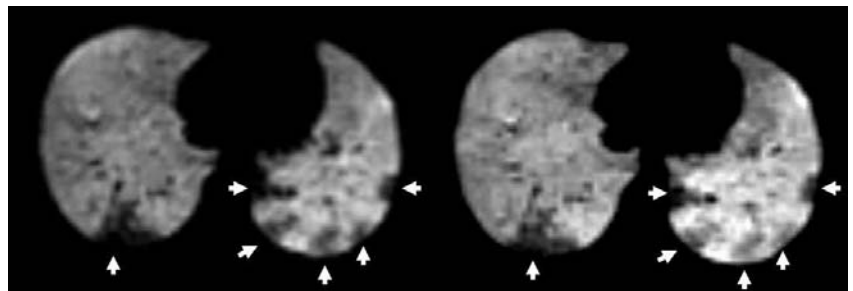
Axial H^3He MR images obtained a few minutes apart demonstrate little variability in location of the ventilation defects.
